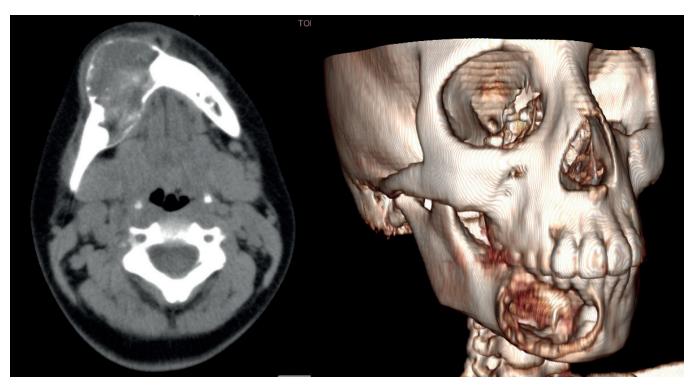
Non-contrast computed tomography of the facial skeleton showing an osteolytic lesion measuring 48 × 32×37 mm with cortical thinning.
